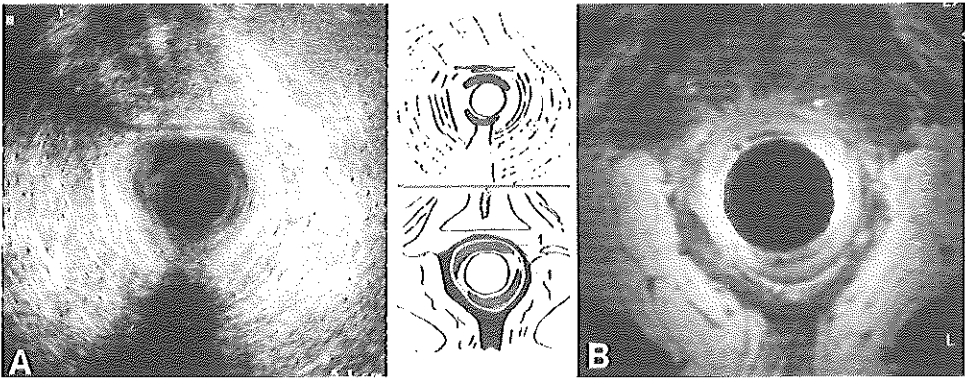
Fragmentation*. Axial sonography (A) and MRI (B) in a female (29) with incontinence after an unwanted anal penetration. The internal sphincter (1) is divided into at least two fragments.
